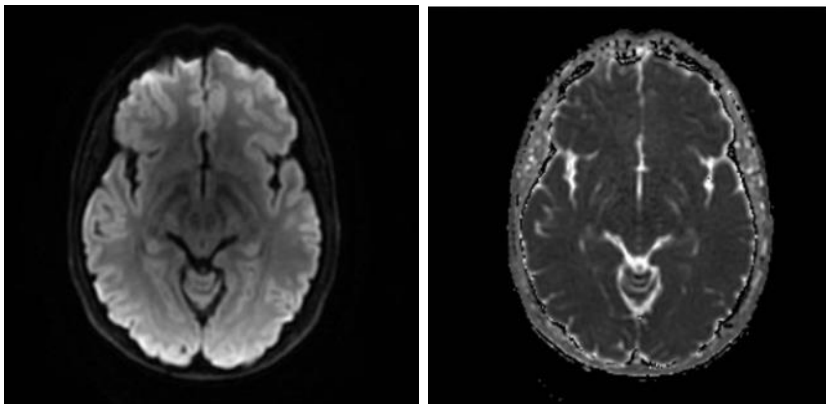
Brain MRI performed after 24 hs of symptoms showed no restrictive images in difussion sequences
